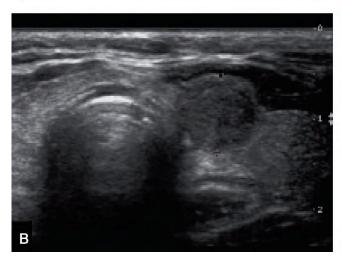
Ultrasound of papillary thyroid carcinoma in the isthmus and left lobe. A, Transverse, 8 x 11 mm. B, Transverse. C, Color Doppler, transverse.
